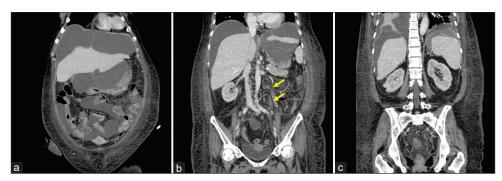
Computed tomography image of the patient's abdomen before tocilizumab treatment. (a-c) Computed tomography images of the abdomen performed 6 months after the initial presentation. Significant anasarca and lymphadenopathy are seen. (a) Loculated ascites, especially at the perihepatic area. (b) Multiple para-aortic lymphadenopathy. (c) Bilateral pleural effusion. The yellow arrow pointed out para-aortic lymphadenopathy
